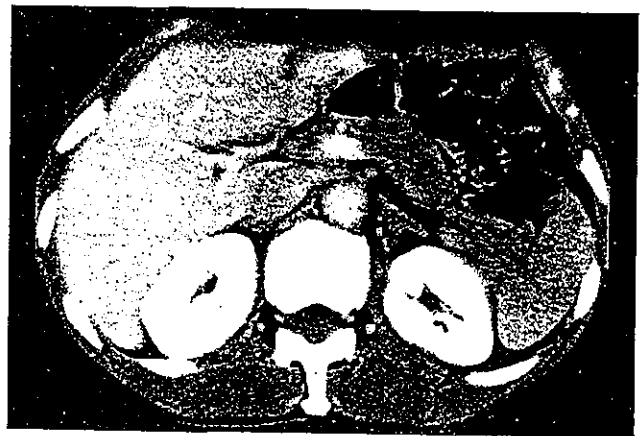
Computed tomography in the patient's uncle displays a pancreatic body mass, 3 cm in diameter
